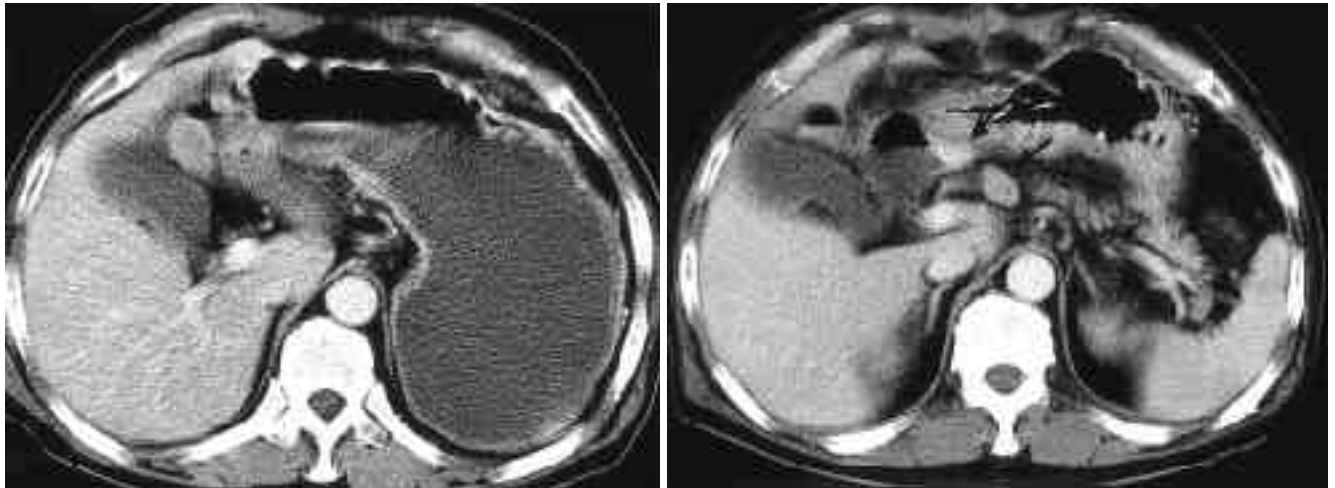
A. Postcontrast CT scan shows gastric distension with massive gastric secretion.
